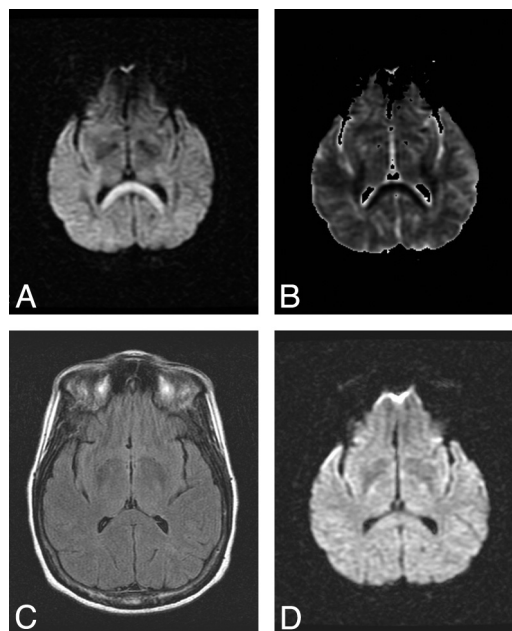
MR images of the brain show DWI hyperintensity in the splenium of the corpus callosum (A) and bilateral parietal lobes with corresponding low signal intensity in the ADC map (B). C, T2-weighted fluid-attenuated inversion recovery (FLAIR) findings are unremarkable. D, Repeat MR imaging shows complete resolution of prior DWI changes. The T2 FLAIR image (C) is unchanged.
